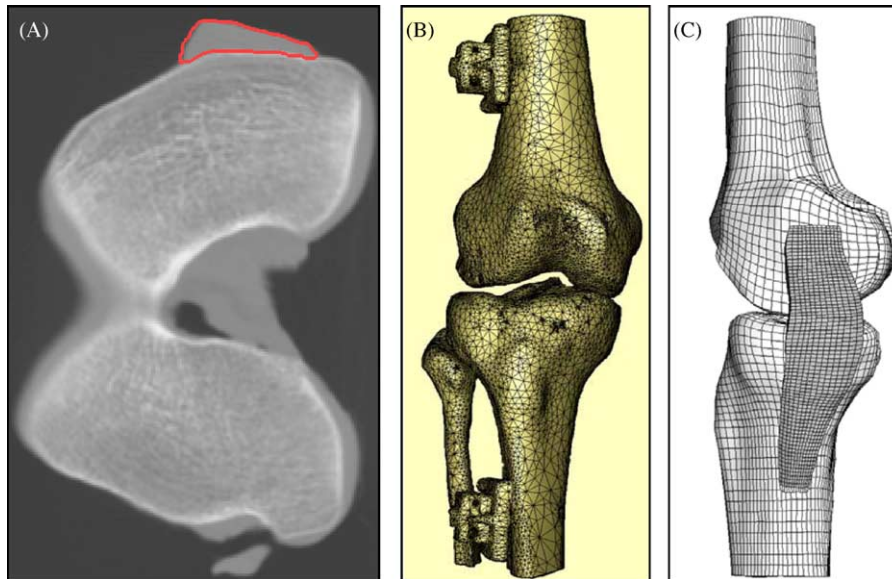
(A) Single CT image slice through the distal femur showing manual segmentation of the MCL (red curve). Top of image is medial, left side of image is anterior. (B) Anterior view of isosurfaces of the femur and tibia extracted from the volumetric CT data using marching cubes. (C) Medial view of hexahedral FE meshes of the femur, MCL and tibia created from manually segmented contours of MCL and isosurfaces of femur and tibia.
